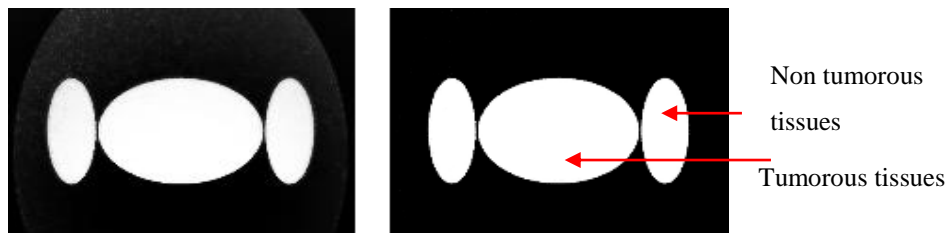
Clusters demonstrated using different grey levels obtained using MFCM from axial MRI slices (first slice: synthetic MRI slice) (red outline: tumour outline). Entire tumour region/s (red outline) is included in a one cluster.
